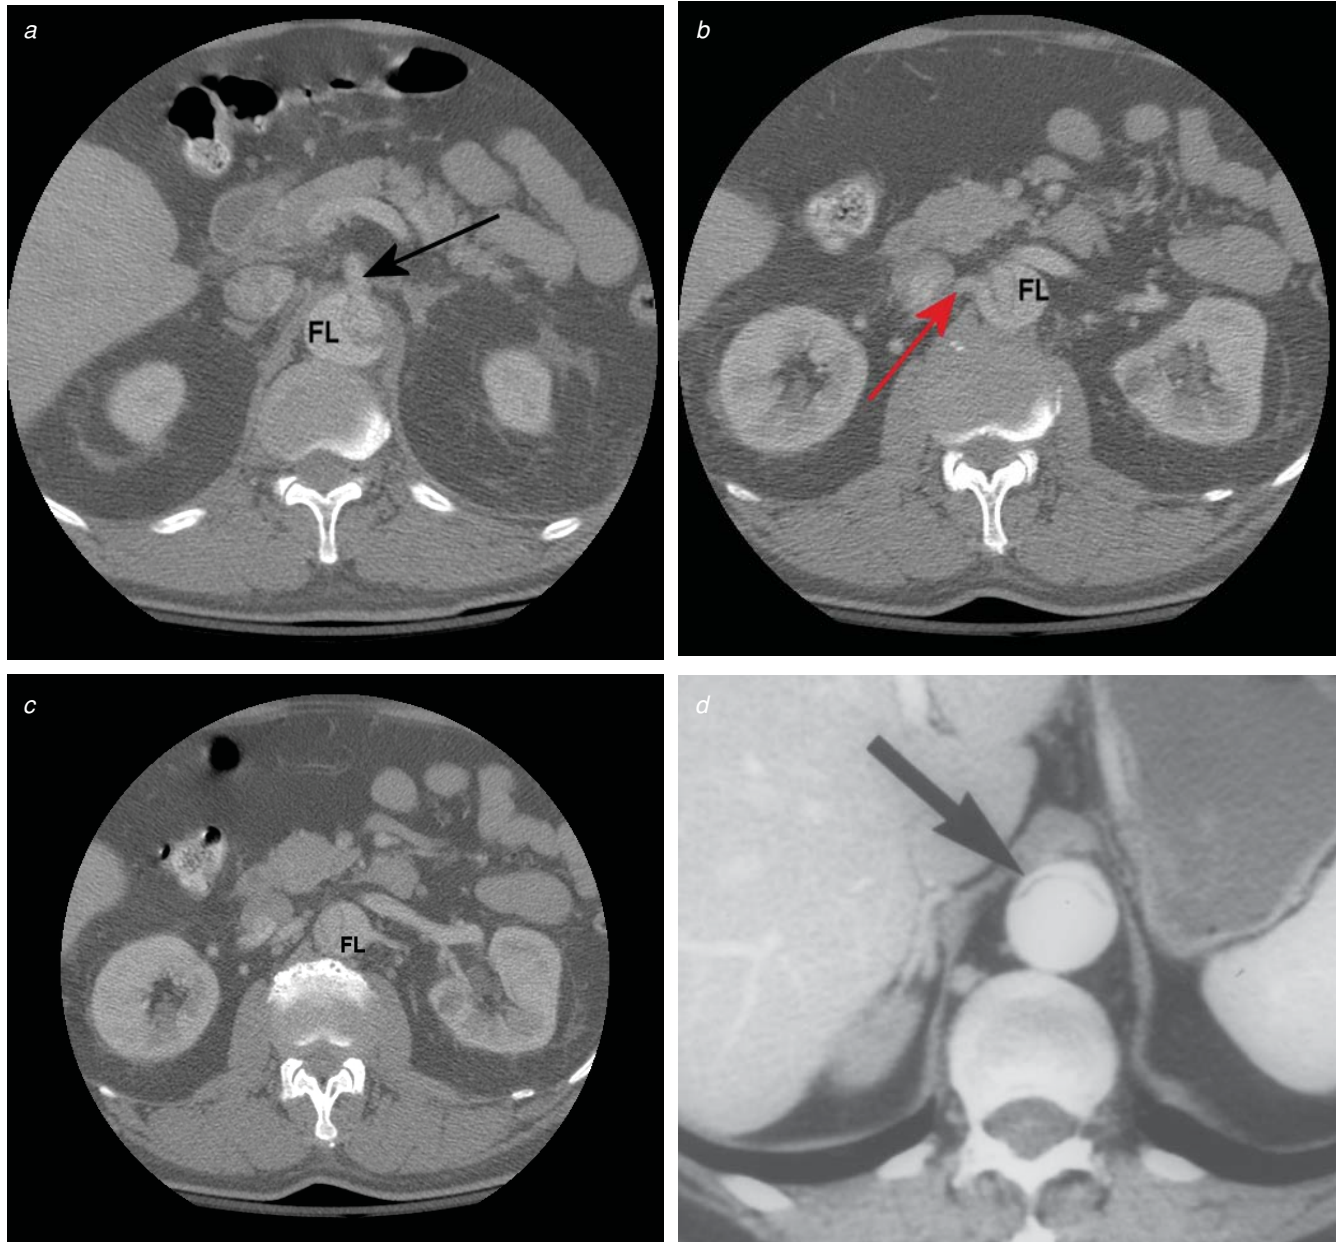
Computed tomographic angiogram findings of acute aortic dissection. (a) Axial image of aortic dissection with the superior mesenteric artery arising from the true lumen (*black arrow*). (b) Axial image of aortic dissection with the right renal artery (*red arrow*) arising from the compressed true lumen. (c) Axial image of aortic dissection with the left renal artery originating from the false lumen. (d) Axial image of aortic dissection with compressed true lumen (*thick arrow*). FL = false lumen.
